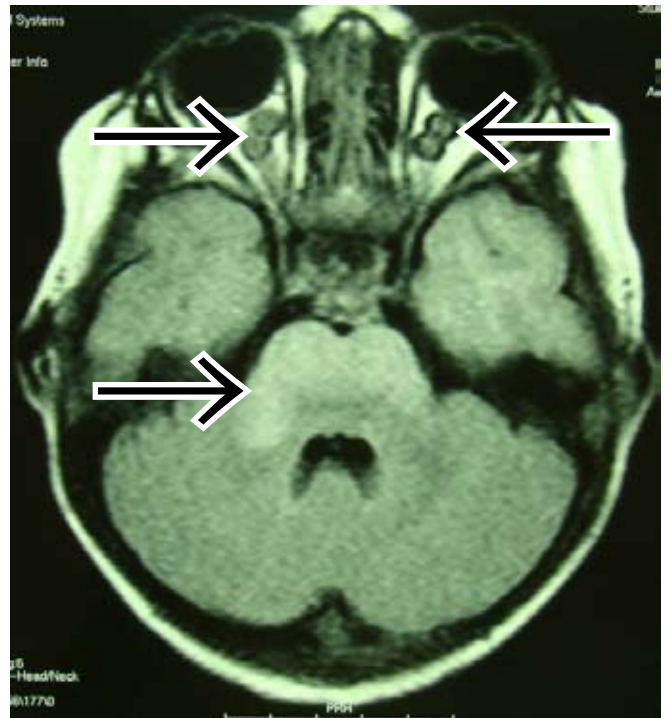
Axial FLAIR MRI sequence demonstrating bilateral optic nerve gliomas and FASI changes in the brainstem.
